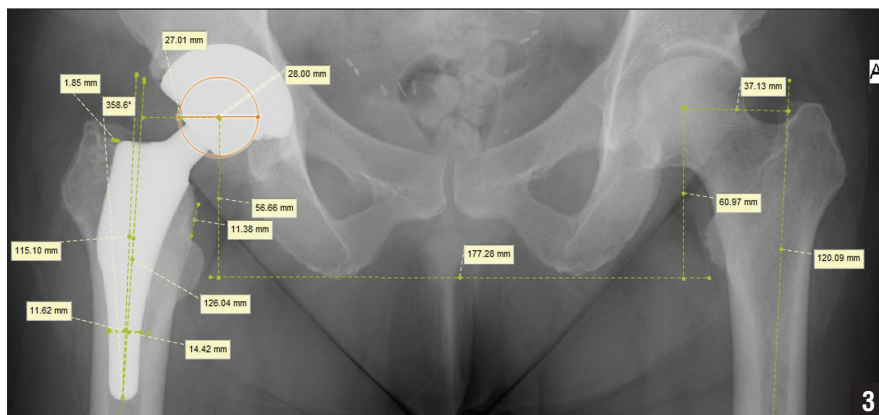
Anteroposterior pelvis radiograph a 62-year-old woman 6 years after a custom short-stem right total hip arthroplasty showing digital radiographic analysis.
